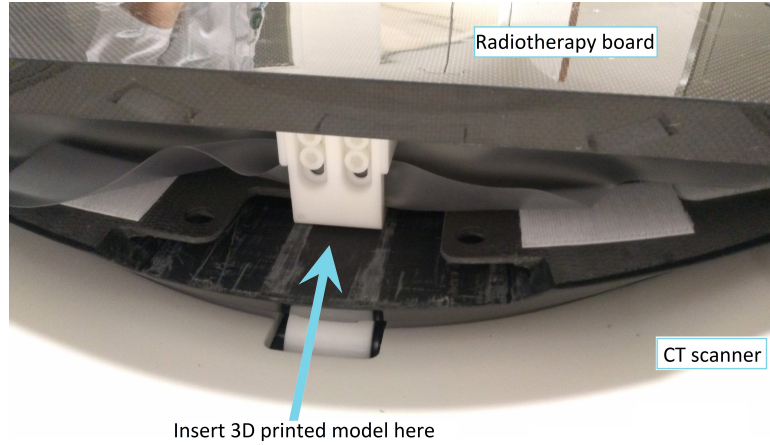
The insertion place of the 3D model within the CT scan
